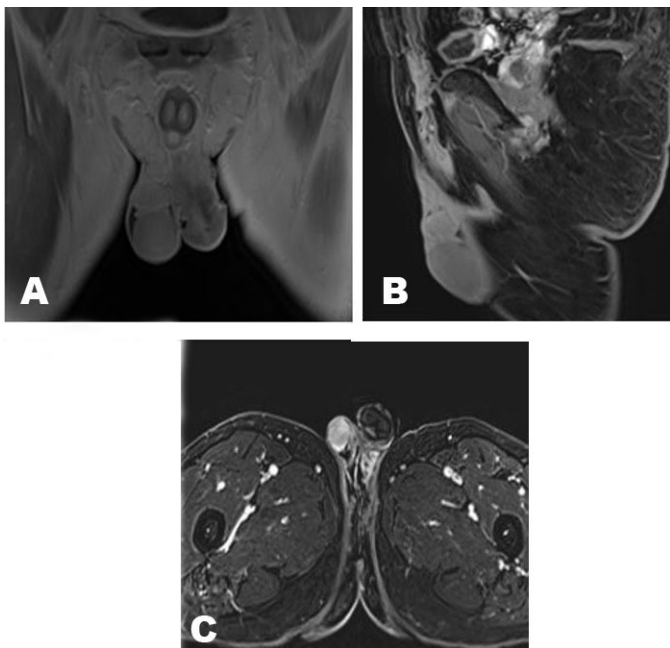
(A–C) MRI showed right extratesticular soft tissue mass not separable from the spermatic cord.
